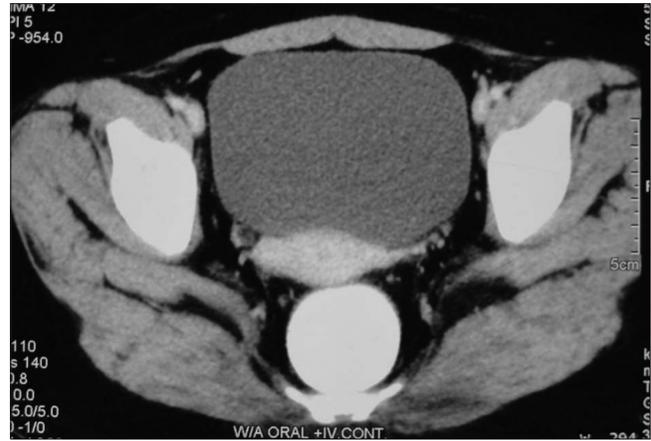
Contrast-enhanced computed tomographic scan of the abdomen and pelvis showing moderately enhanced bulky cervix with paracervical fat stranding and nodularity, without any locoregional lymphadenopathy
